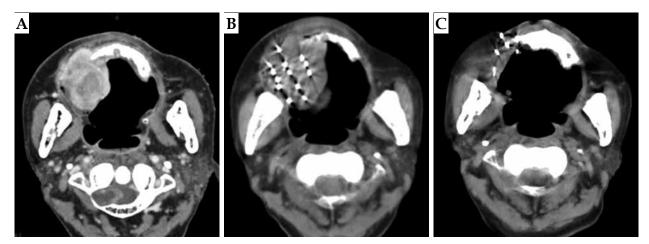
A case of hypofractionated sarcoma of the right maxillary sinus. Enhanced CT of patient's head showed space occupying lesions of the right maxillary alveolar bone and maxilla, with destruction of the skull base. Because the patient was 81 years old, the tumor had a wide range of invasion, and it was an undifferentiated sarcoma, with a high degree of malignancy. The trauma of operation was great, and the quality of life was affected after the surgery. The patient and his family were informed, and refused the operation after comprehensive consideration. Finally, the patient chose SABT. A) Pre-operative CT localization images; B) After implantation of seeds; C) Post-operative review at 18 months
